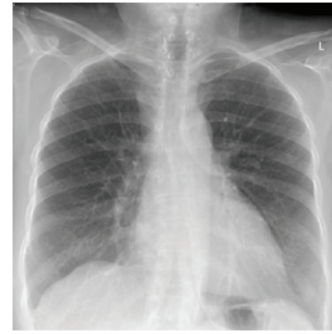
Chest X-ray post-operative showing regression of the superior mediastinum after the surgical resection of the large RSG.
